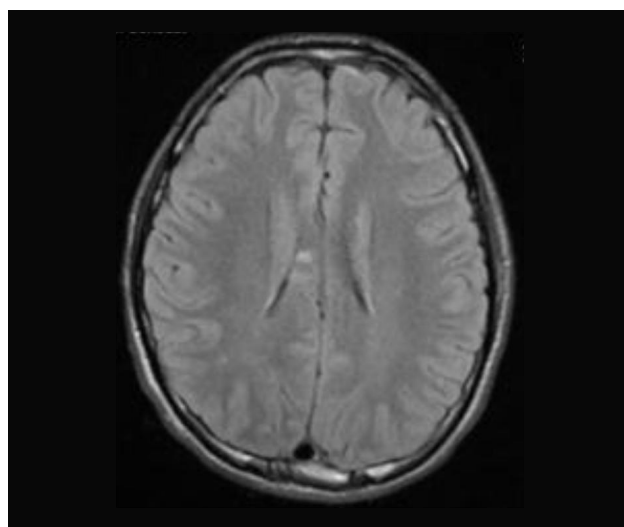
T2-weighted axial FLAIR showed two hyperintensity lesions at the body of right corpus callosum and diagnosed of diffuse (traumatic) axonal injury grade II.
